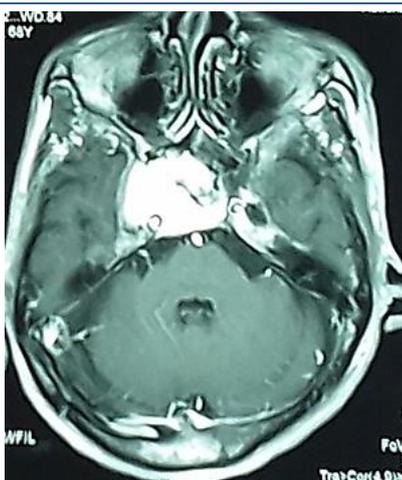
FLAIR contrast MRI; intermediate, homogeneously contrast enhancing mass lesion arising from the right sphenoid wing with local infiltration.
